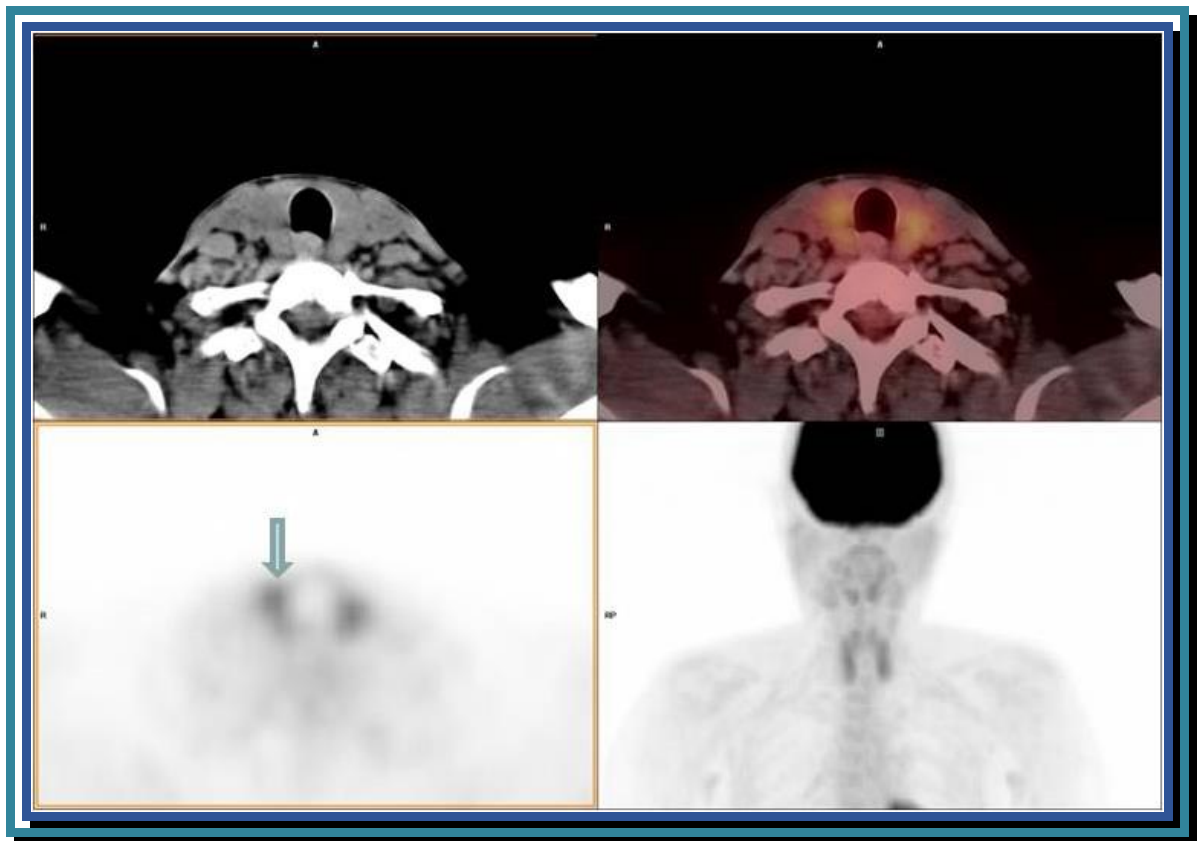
Captación tiroidea de 18-FDG en uno de los pacientes de nuestro estudio que había captado a su vez en el oído interno (Figura 7). Esta captación era desconocida y fue luego confirmada de origen autoinmune.
